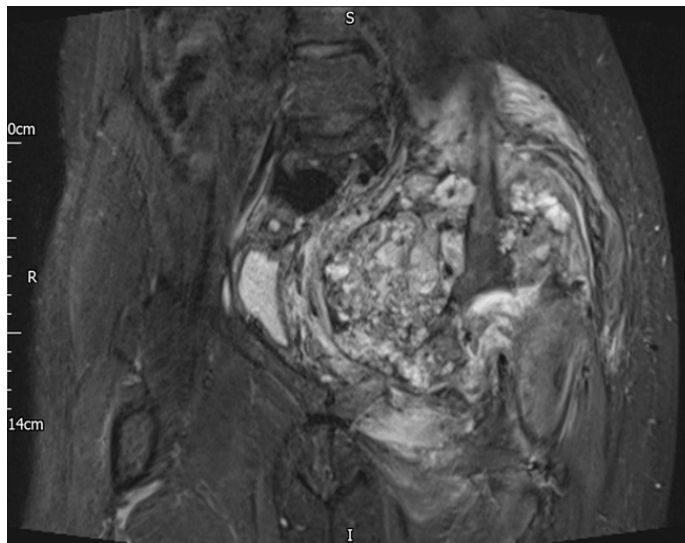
Magnetic resonance imaging shows an extensive bone forming. The tumour has multiple fluid-fluid levels and extended into the pelvis and eroded the hip.
